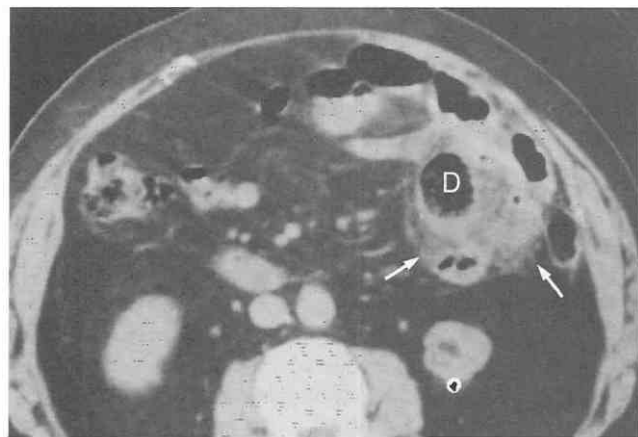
Jejunal diverticulitis. CT scan shows diverticular abscess (D) and diffuse perienteric haziness and infiltrates (arrows). (Courtesy of K. C. Cho, Newark, New Jersey.)
